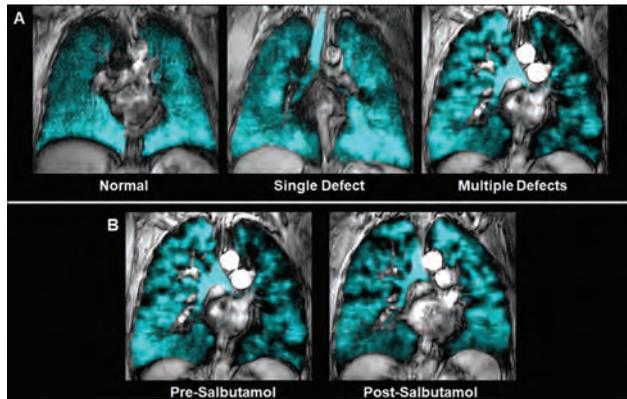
(A) <sup>129</sup>Xe MRI ventilation images showing three ventilation patterns: Normal, Single Defect and Multiple Defects. (B) <sup>129</sup>Xe MRI ventilation images showing partial improvement after salbutamol administration.
